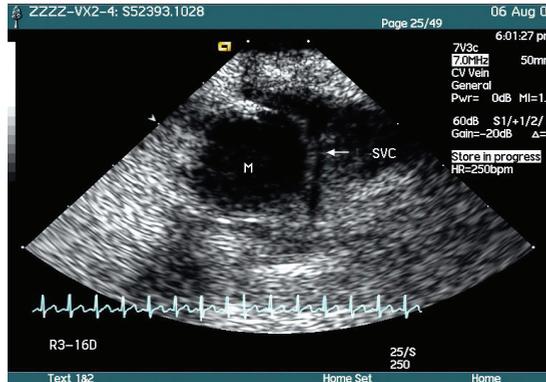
Two-dimensional ultrasonography of a rabbit with SVCO
